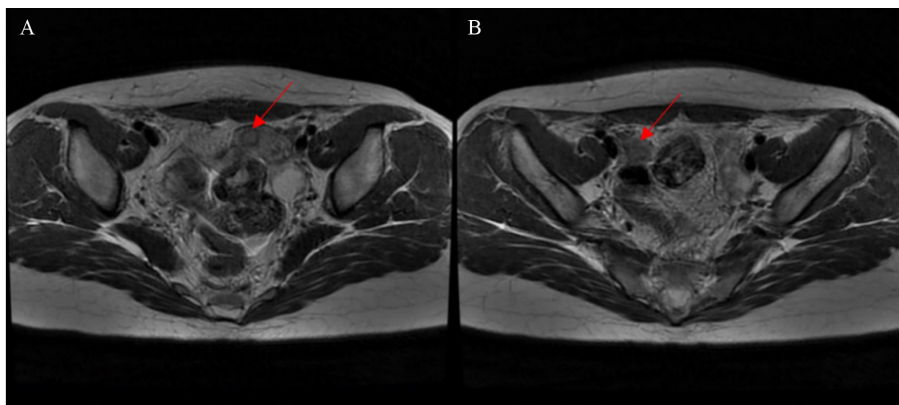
MR images of the existence of endometrial tissues in rudimentary uterus. (A) Axial fat-saturated T2W1 MR image shows endometrial tissues in the left rudimentary uterus (red arrow) and (B) no endometrium is detected in the right rudimentary uterus (red arrow).
